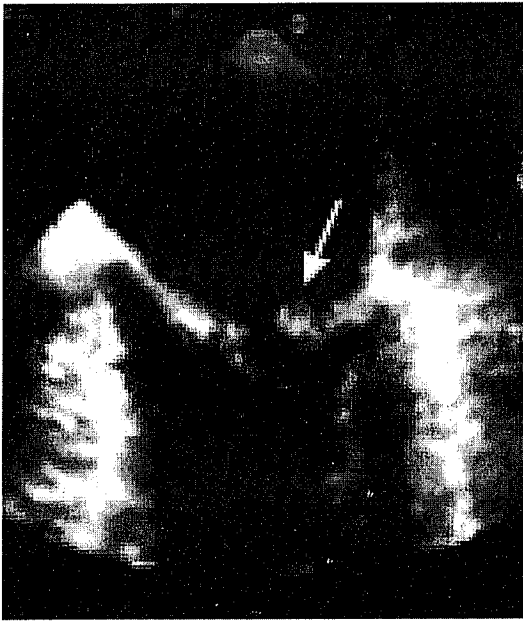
Transesophageal echocardiogram revealed a Libman-Sacks vegetation.
